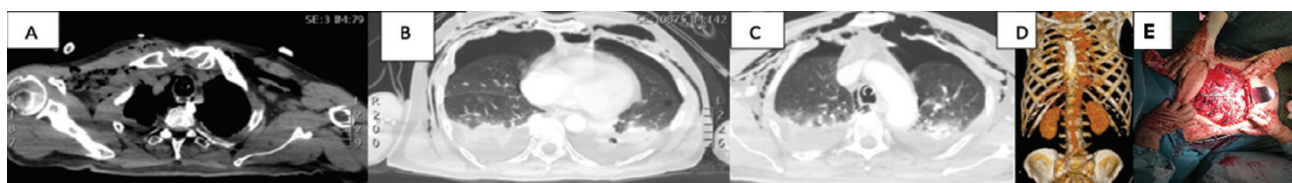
Computed tomography scan showing left pneumothorax, pneumomediastinum, multiple rib fractures (A, B, C) and 3D reconstruction of blood vessels (D). Surgical stabilization of the rib fractures using synthetic plates (E).
